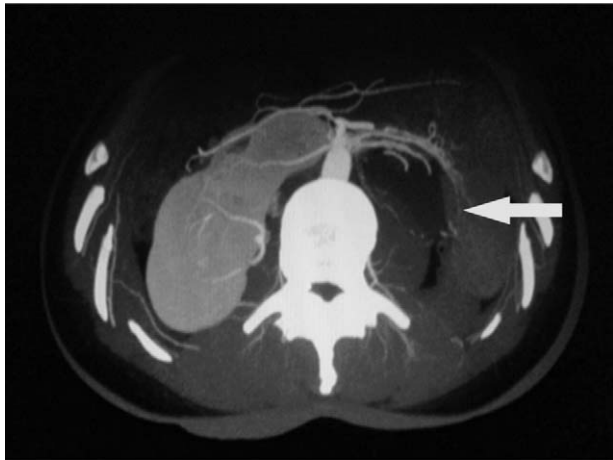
Computed tomography demonstrates the hydronephrotic left moiety with a very thin cortex (arrow) of the horseshoe kidney.
